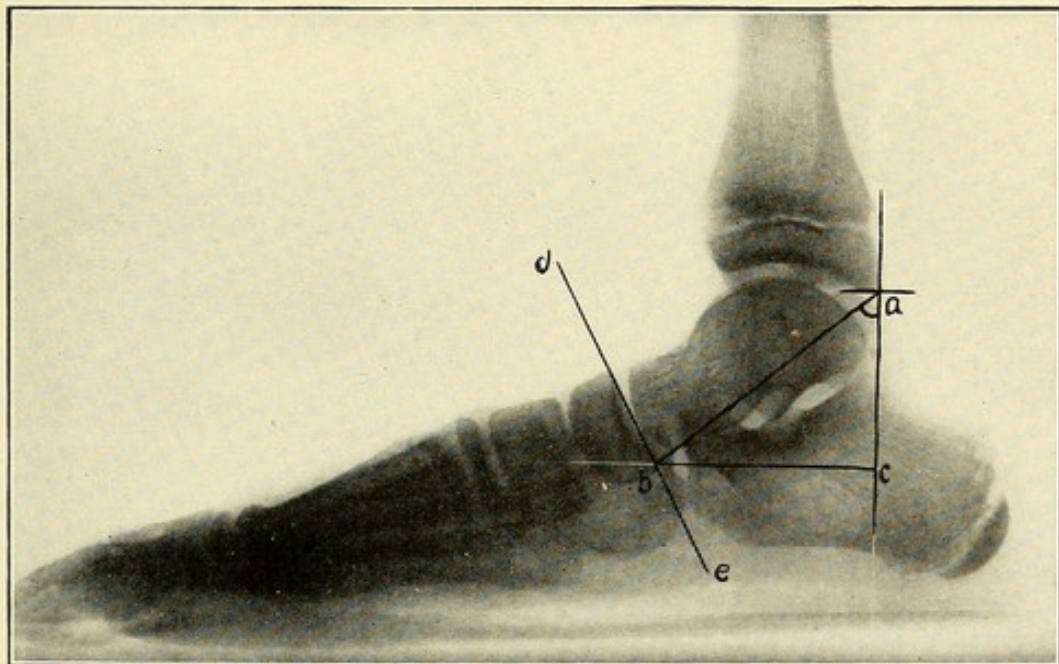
Roentgen picture of same foot with weight-bearing. Same points marked. *b-c* here is less than in previous picture. Angle *b-a-c* also less, *d-e* inclines more.
